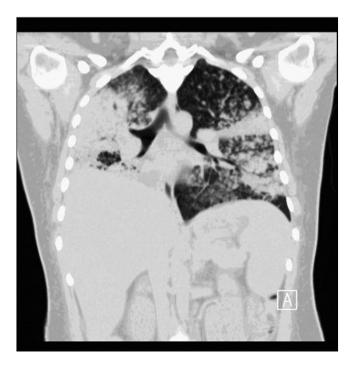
CT chest without intravenous contrast obtained on admission. This coronal view shows dense consolidation in the left upper lobe, the right middle lobe, and the right lower lobe.
